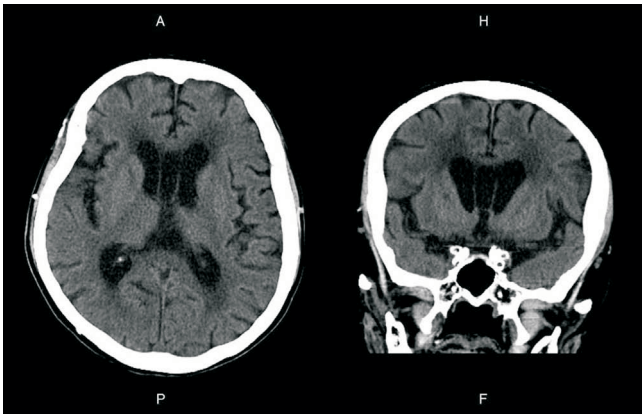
Brain CT revealed no evidence of intracranial bleeding, an organic brain lesion or acute infarction.
